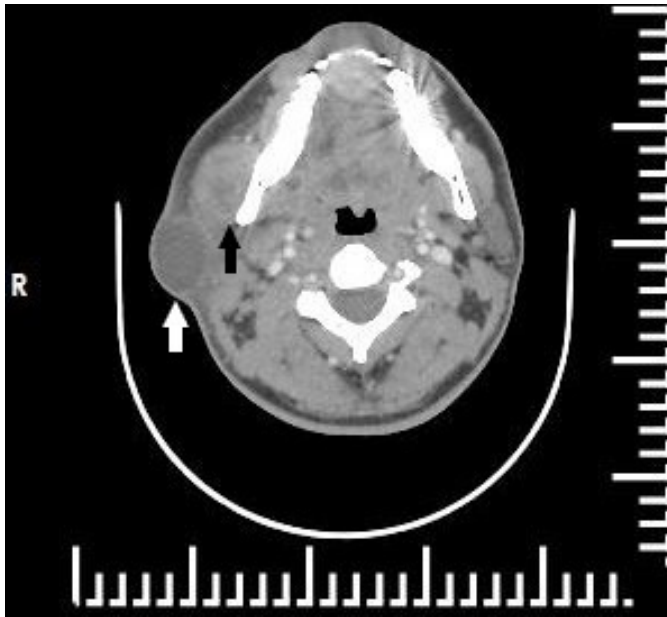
Enhanced computed tomography image shows right parotid gland lesions both in the superficial lobe with thin-walled ring enhancement (white arrow) and anterior to the masseter muscle in the deep lobe (black arrow) with a larger axial diameter of 40×22 mm and fuzzy adjacent fat tissue
